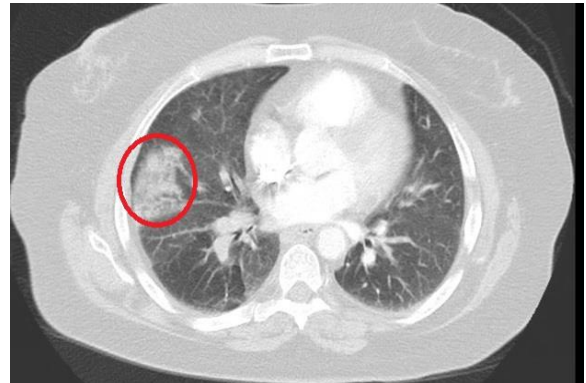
A computed tomography angiogram (CTA) of the chest in a lung window demonstrates a wedge-shaped opacity in the right middle lobe consistent with a Hampton hump (red circle).
